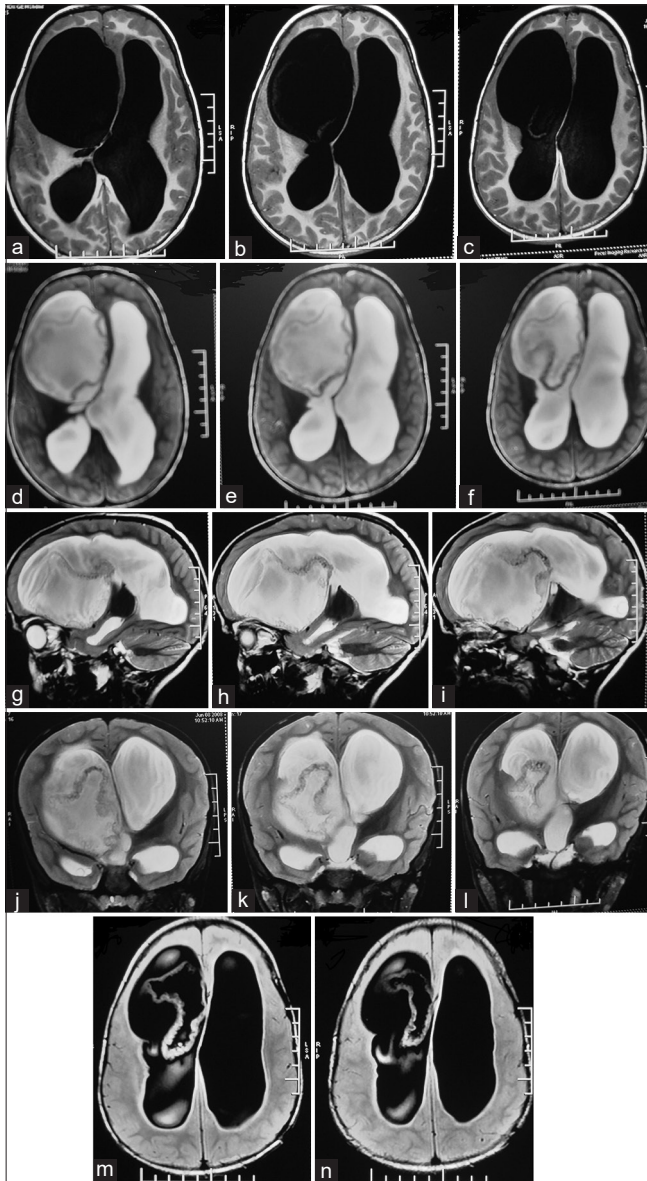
(a-c) T1 MRI axial image sequences showing hypointense intraventricular cyst 1 (d-f) T2 MRI axial image sequences showing hyperintense intraventricular cyst with ruptured hypointense wall in the right lateral ventricle (Camalote sign) 1 (g-i) T2 MRI Saggital image sequences again showing the ruptured cyst and cyst wall sedimenting down 1 (j-l) T2 MRI Coronal image sequences confirming the ruptured hydatid cyst1. (m and n) MRI FLAIR images in axial cuts distinctly defining the cyst wall.
